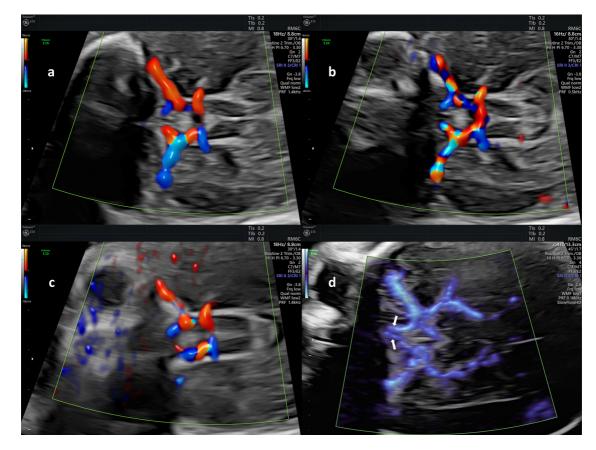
Fetal circle of Willis obtained using conventional ultrasound Doppler and its artifacts versus Slow*flow*HD small vessel visualization. (a) Conventional color Doppler with correct Doppler adjustments. (b) Conventional color Doppler with aliasing artifact evident owing to pulse repetition frequency (PRF) set to 0.5Khz (too low). (c) Conventional color Doppler with color flash artifact caused by a tiny fetal movement with a low PRF set to 1.4 kHz. (d) Slow*flow*HD Doppler correctly revealing slow-velocity vessels with the PRF set to 0.18 kHz, most notably evident for the clearly visualized bilateral anterior cerebral arteries (d, *white arrows*), which are not visualized in (a)–(c).
